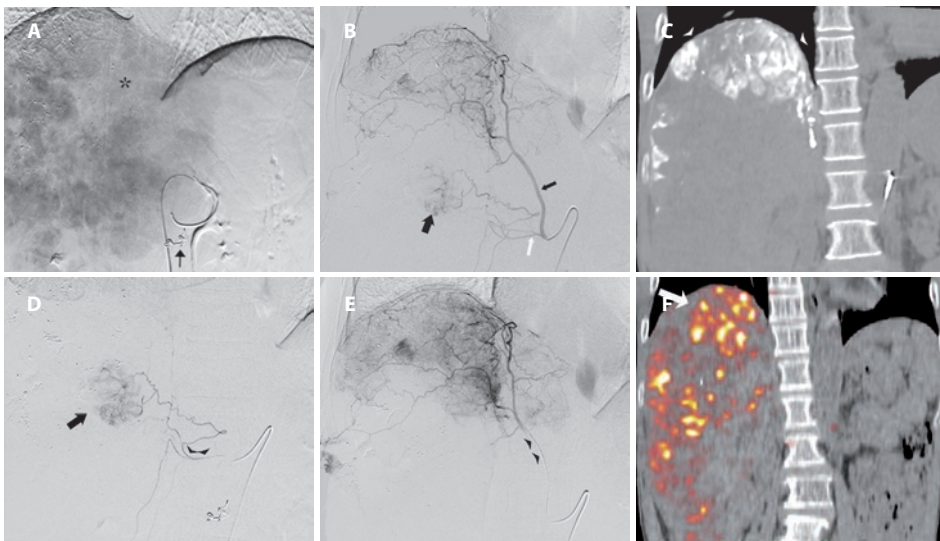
Images from 52-year-old male with a HCC in segment 4, 5, 6, 7 and 8. (a) DSA from the proper hepatic artery shows the large hypervascular tumor. Poor enhancement of the cranio-medial area is seen (asterix). Embolization of the gastroduodenal artery and right gastric artery has been performed with respectively an Amplatzer vascular plug 4 and microcoils (black arrow). (b) DSA from the right IPA (small black arrow) shows enhancement of the cranial portion of the tumor and supply to a small tumor area (large black arrow) through a proximal adrenal artery branch (white arrow). (c). CTHA from the IPA shows enhancement of the cranial tumor part (arrowheads). (d) DSA from the adrenal artery through a microcatheter (arrowheads) shows the small area of tumor enhancement (arrow). The adrenal artery was embolized using PVA particles. (e) After placement of the microcatheter (arrowheads) more distally into the IPA, Y90 microspheres were infused. This was followed by infusion into the proper hepatic artery. (f) PET/CT performed 1 day after radioembolization shows higher Y90 activity in the IPA territory (arrow) compared to the rest of the tumor.
